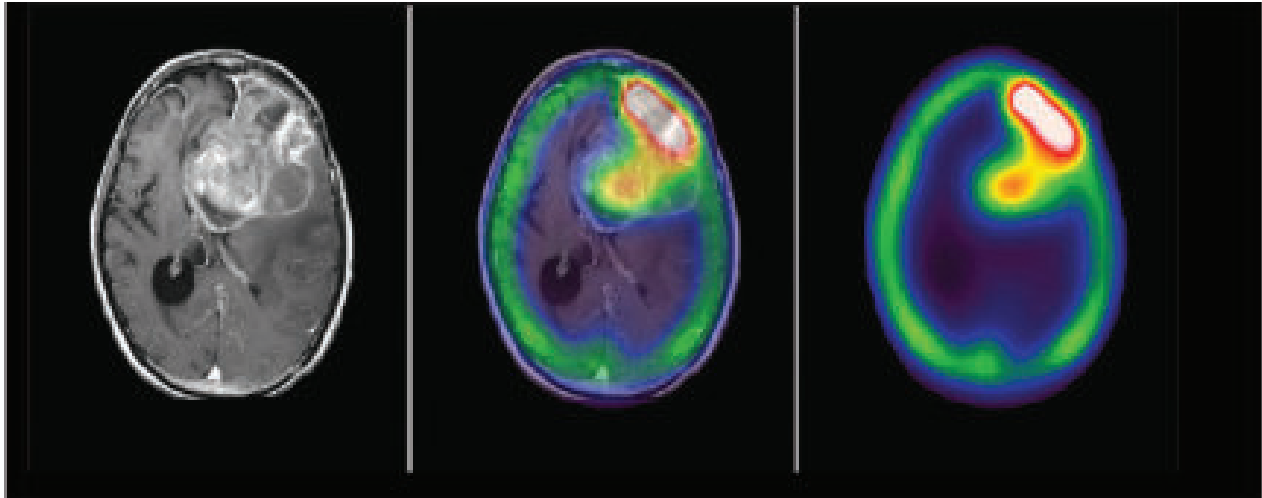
Tc-99m GHA SPECT (Tc-99m glucoheptonate) shows anaplastic oligodendroglioma of the left prefrontal region.
